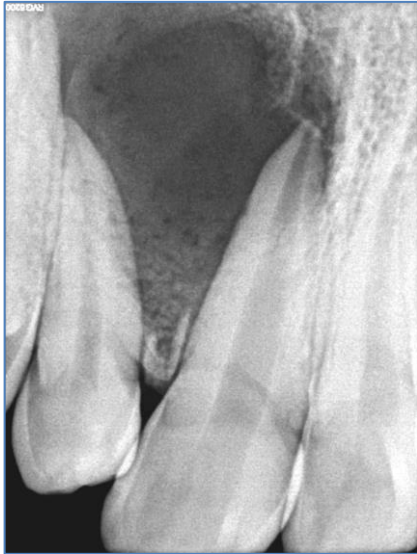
Intraoral periapical radiograph showing large periapical lesion involving the apices of maxillary right central and lateral incisors.
